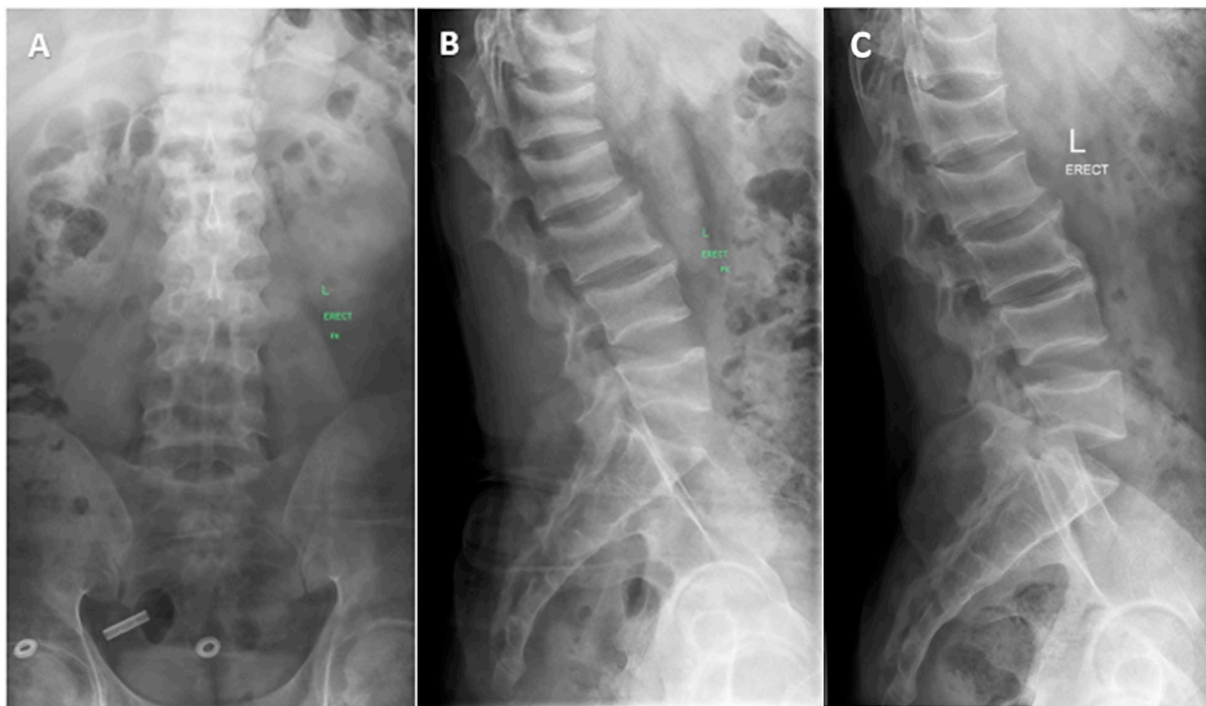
Spinal X-rays demonstrating healing of ‘rugger jersey spine’
